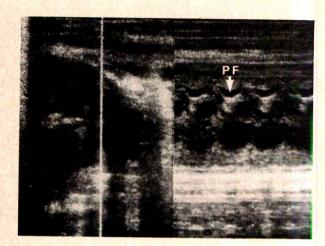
M-mode directed two-dimensional echocardiography. The cursor is at the level of the arrows in Fig. 1. A clear-cut pericardial fluid *(PF)* layer is demonstrated *(arrow)*.
